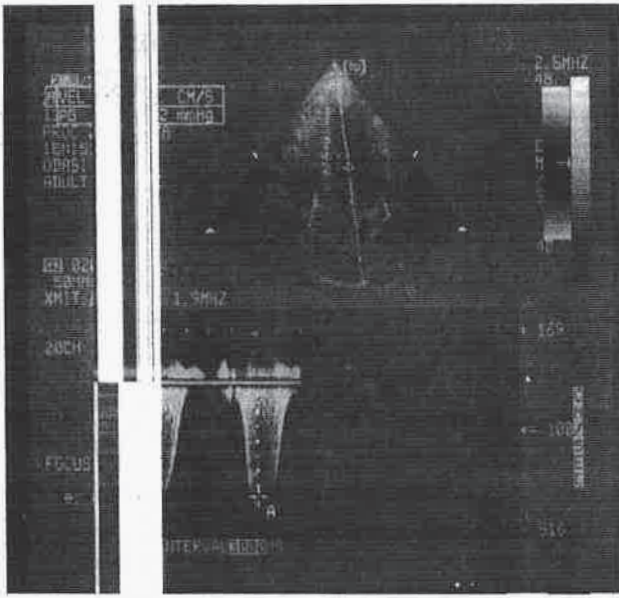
Apical four-chamber view of the left ventricle at the systole showing continuous-wave Doppler tracing of abnormal systolic velocity pattern.
